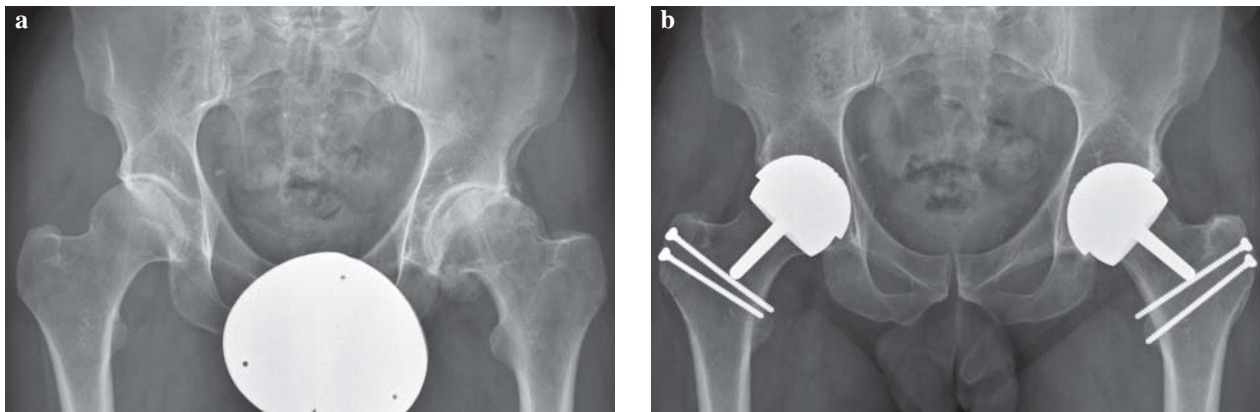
(a) Radiograph of a 52-year old male patient who suffered from bilateral osteoarthritis. (b) The patient was treated by a two stage bilateral HRA using an open surgical dislocation technique with a step osteotomy of the greater trochanter.
